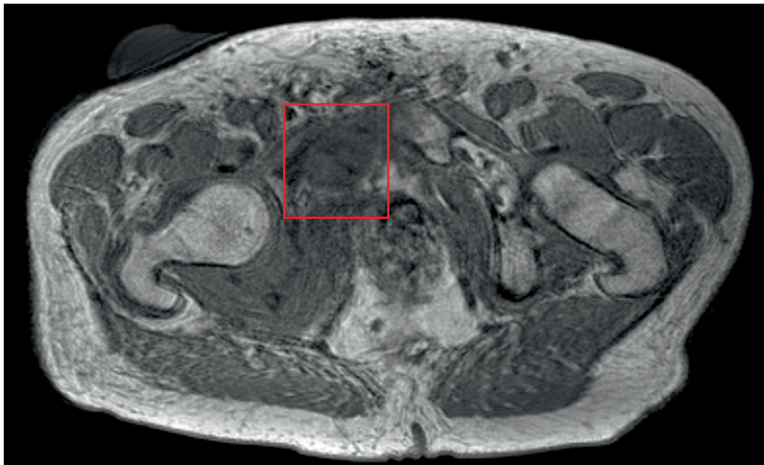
S3: Example of pretreatment MR image with motion artefacts (P1). The lesion is indicated by a red square.
